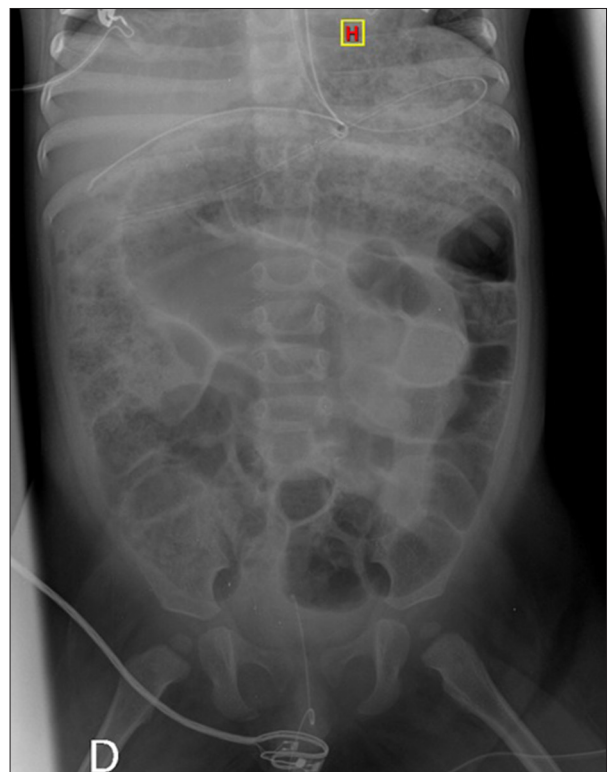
Abdominal x-ray with gastric and intestinal dilatation.
